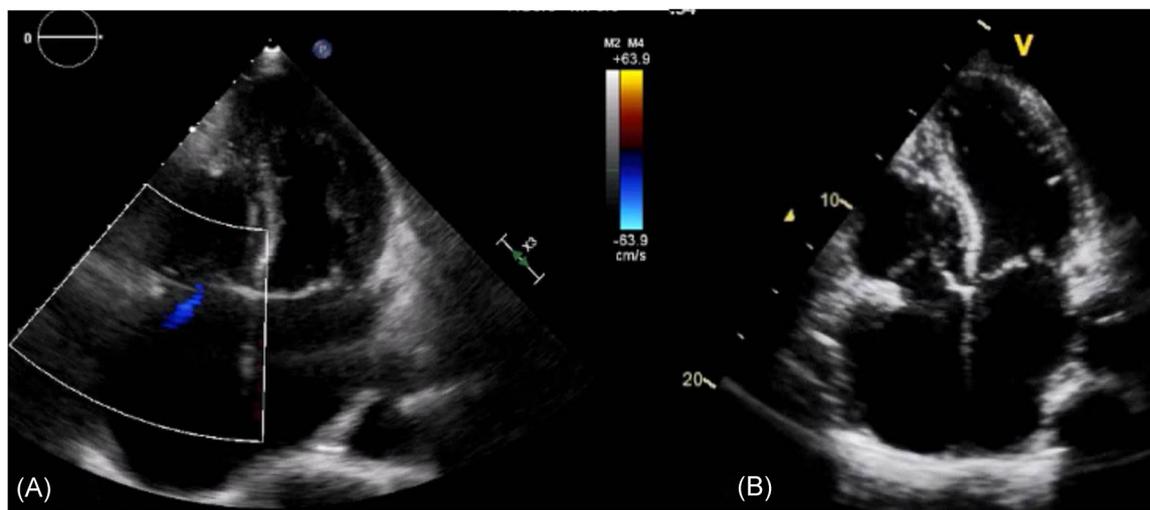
Panel A and B Transthoracic echocardiography at 1-year follow-up from the procedure
